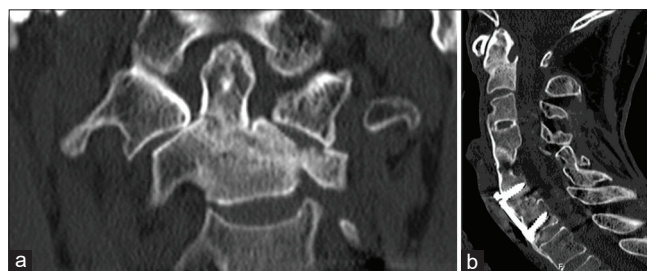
(a) Two months postodontoid fracture computed tomography (CT) scan, coronal view. (b) Two months postodontoid fracture CT scan, sagittal view.
